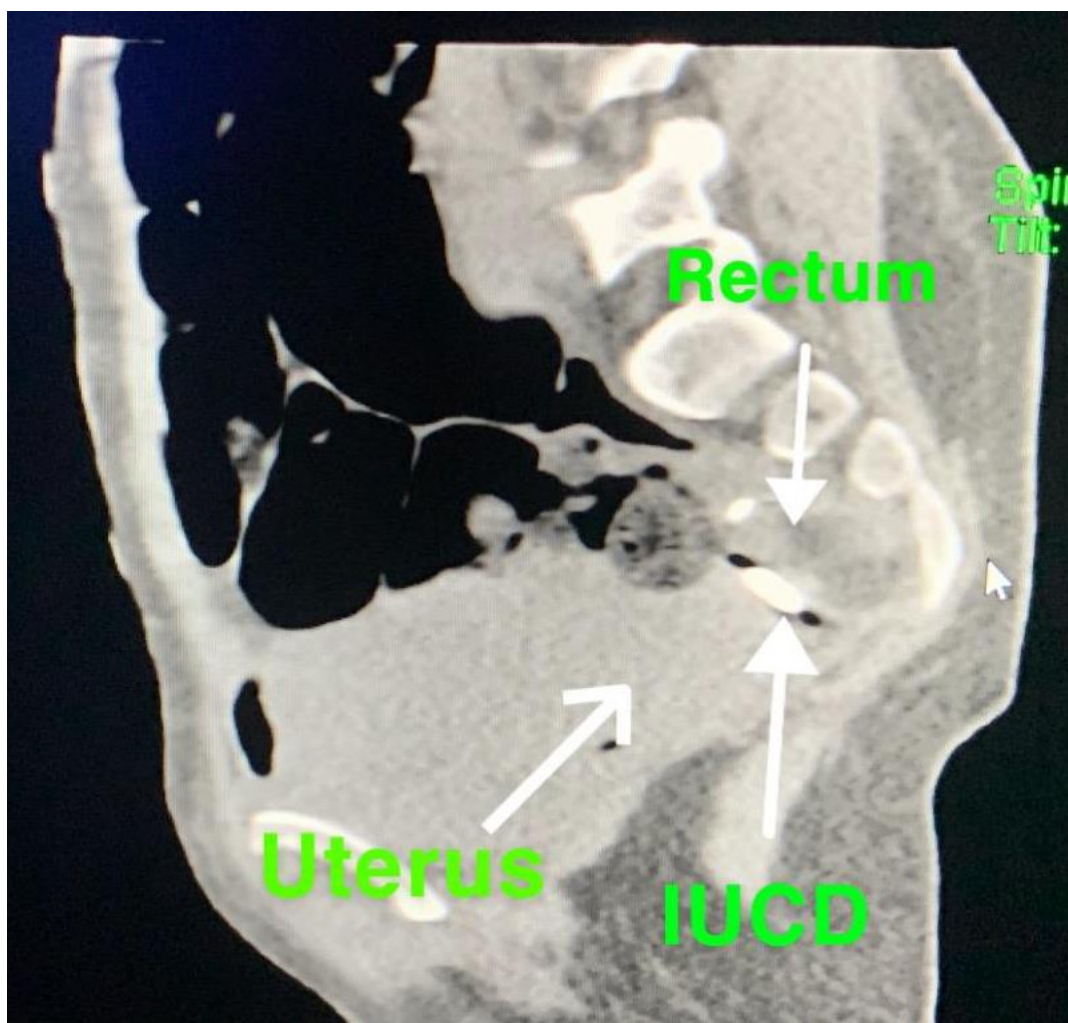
CT pelvis without contrast showing that the IUD is seen outside the uterus in the pelvis posteriorly in the right side at the posterior aspect of the pelvis. There is large swelling seen within the uterus due to bulky uterus which is related to the pregnancy
